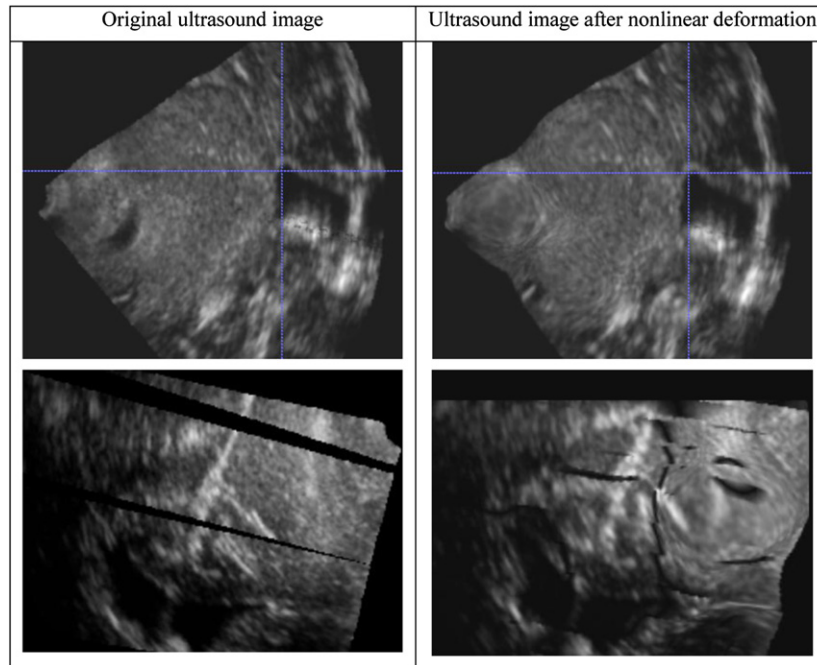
Examples of artifacts caused by nonlinear deformation of ultrasound images. Original ultrasound image (left). After nonlinear resampling (right).
